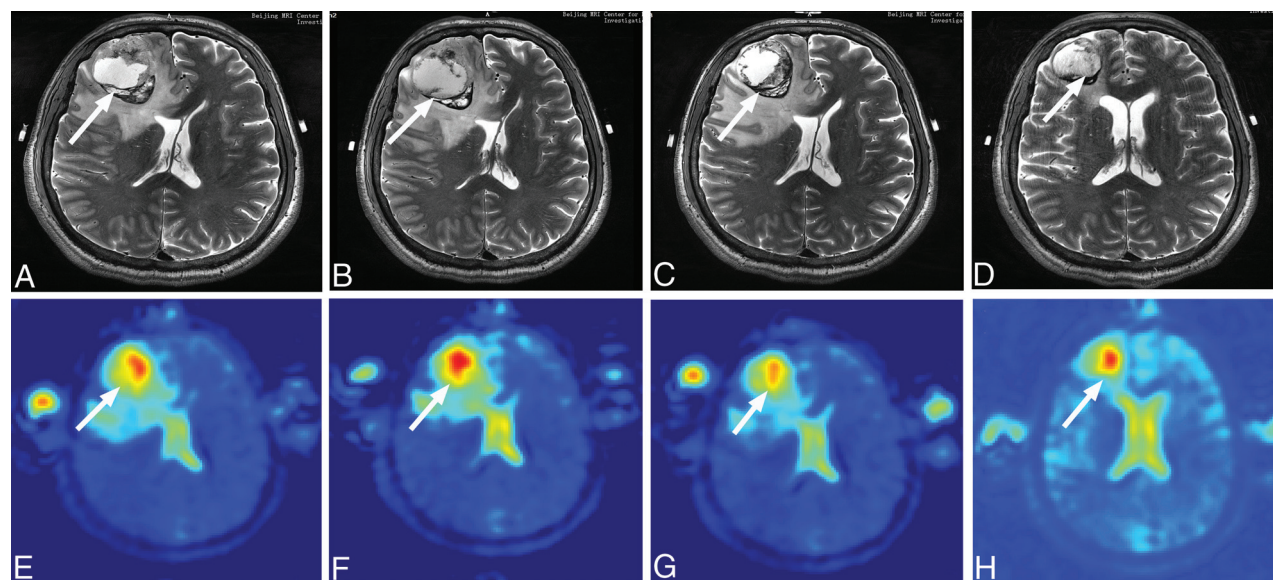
A, Axial T2-weighted image showing brain metastasis of pulmonary neuroendocrine carcinoma complicated with adenocarcinoma (tumor 14). B, T2-weighted image 48 hours after CK. C, T2-weighted image 1 week after CK. D, T2-weighted image 1 month after CK. E, Sodium MR imaging pretreatment. F, Sodium MR imaging 48 hours after CK. G, Sodium MR imaging 1 week after CK. H, Sodium MR imaging 1 month after CK. The arrows pointed to the metastasis.
